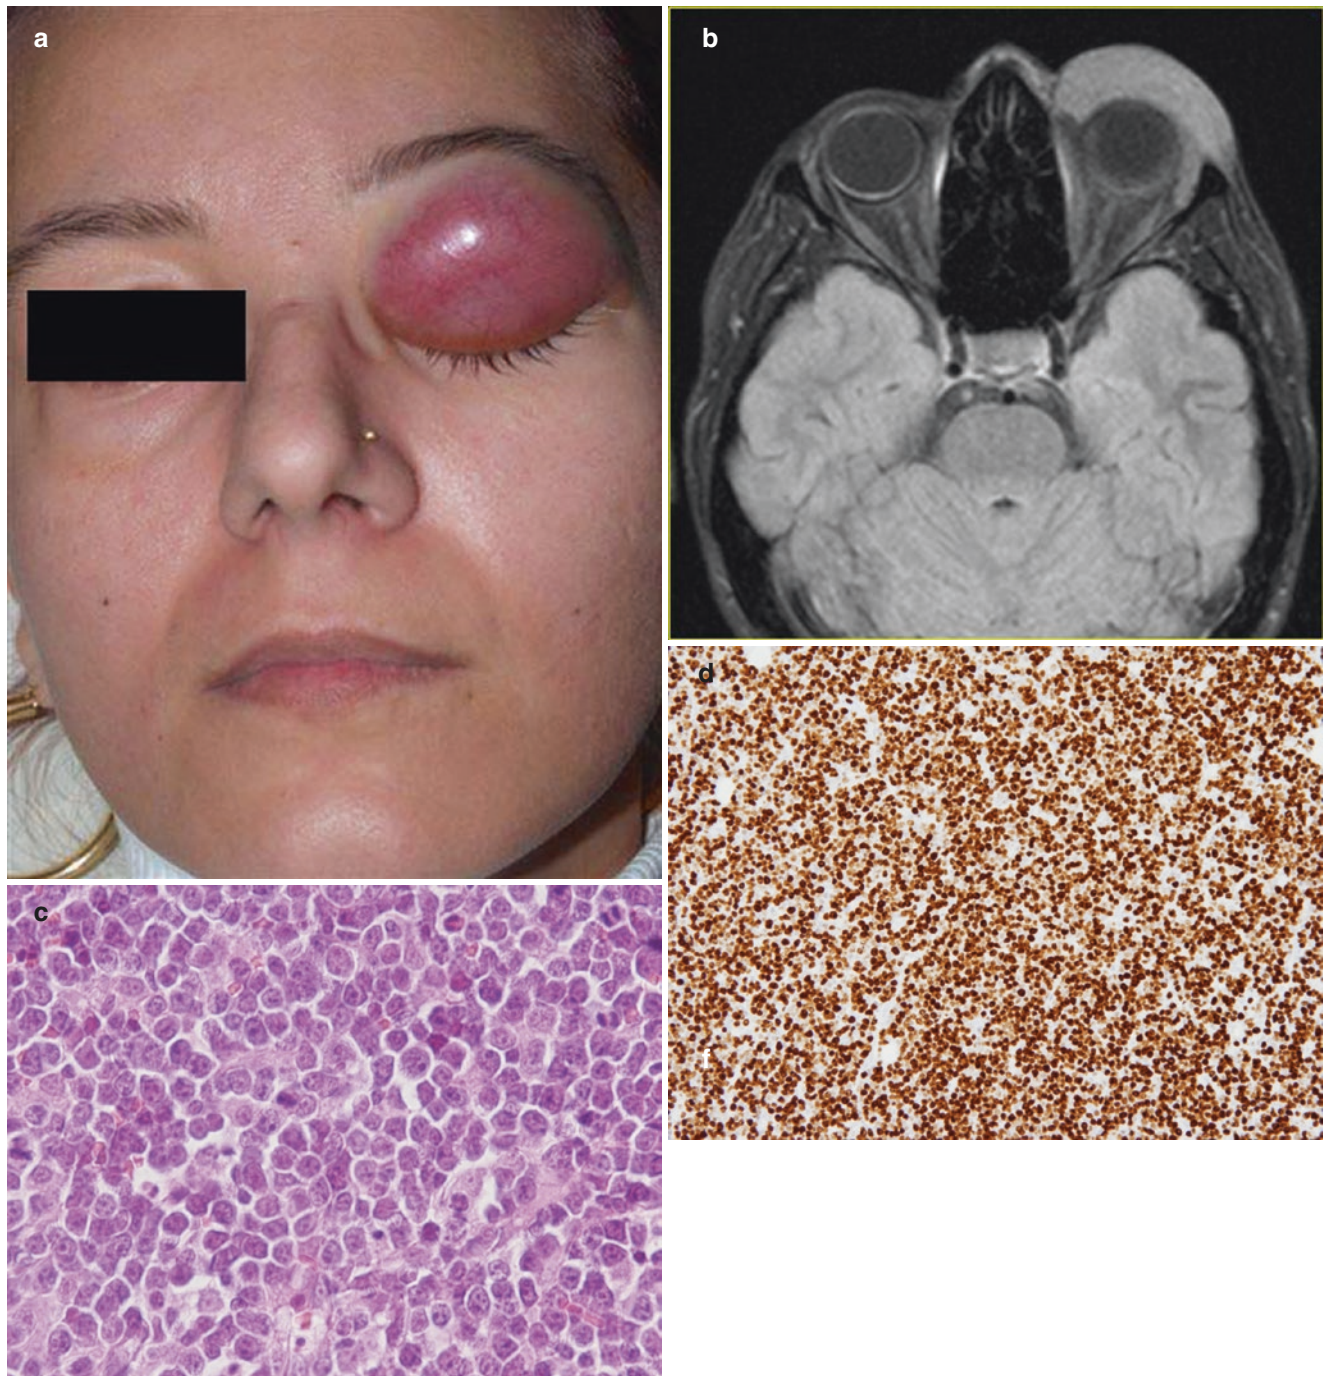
(a) Diffuse large B-cell lymphoma. Young woman with a DLBCL in the left eyelid (Courtesy of Dr. P. Claros, Barcelona, Spain). (b) CT scan in the same young woman displaying a mass in the left
